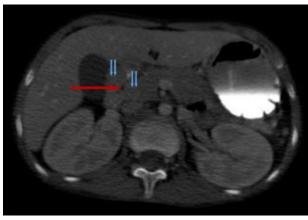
Blue arrow: CT image showing the head of the pancreas surrounding D2, Red arrow: CT image of the D2
